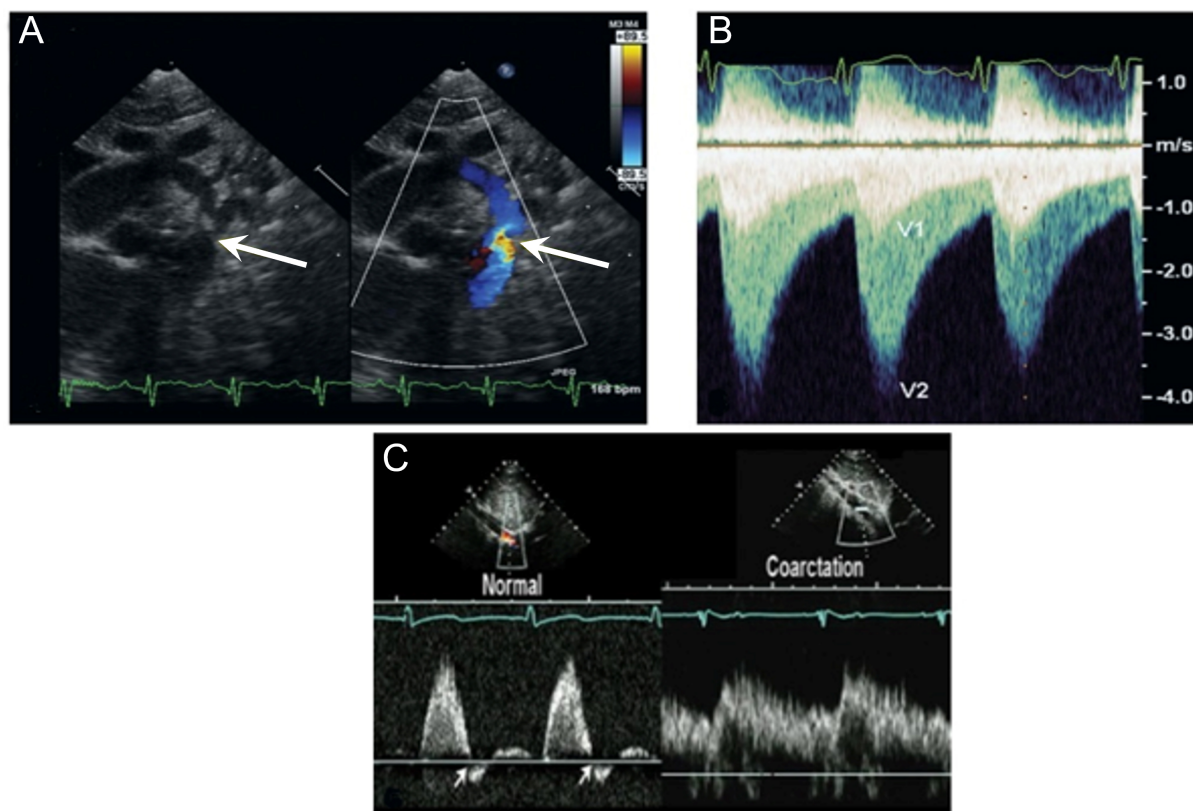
Echocardiographic evaluation of coarctation of the aorta. (Modified from Patel A and Young LT. Abnormalities of the aortic arch. In [10]; used with permission of Mayo Foundation for Medical Education and Research.) (A) 2-dimensional imaging (left) shows a discrete coarctation (arrow). Color flow (right) shows aliased flow in the area of obstruction (arrow). (B) Continuous-wave Doppler signal, obtained with a non-imaging probe from the suprasternal notch, shows the characteristic “sawtooth” flow pattern, with antegrade flow extending into diastole. Flow proximal to the coarctation (V1) and high-velocity flow across the coarctation site (V2) can be seen. (C) Pulsed-wave Doppler evaluation of the abdominal aorta at the diaphragm shows a brisk upstroke and downstroke with the presence of an early diastolic flow reversal (EDR) signal (arrows). This signal excludes a diagnosis of proximal obstruction in the thoracic aorta. The right portion shows delayed upstroke and downstroke and absent EDR, indicating coarctation.
